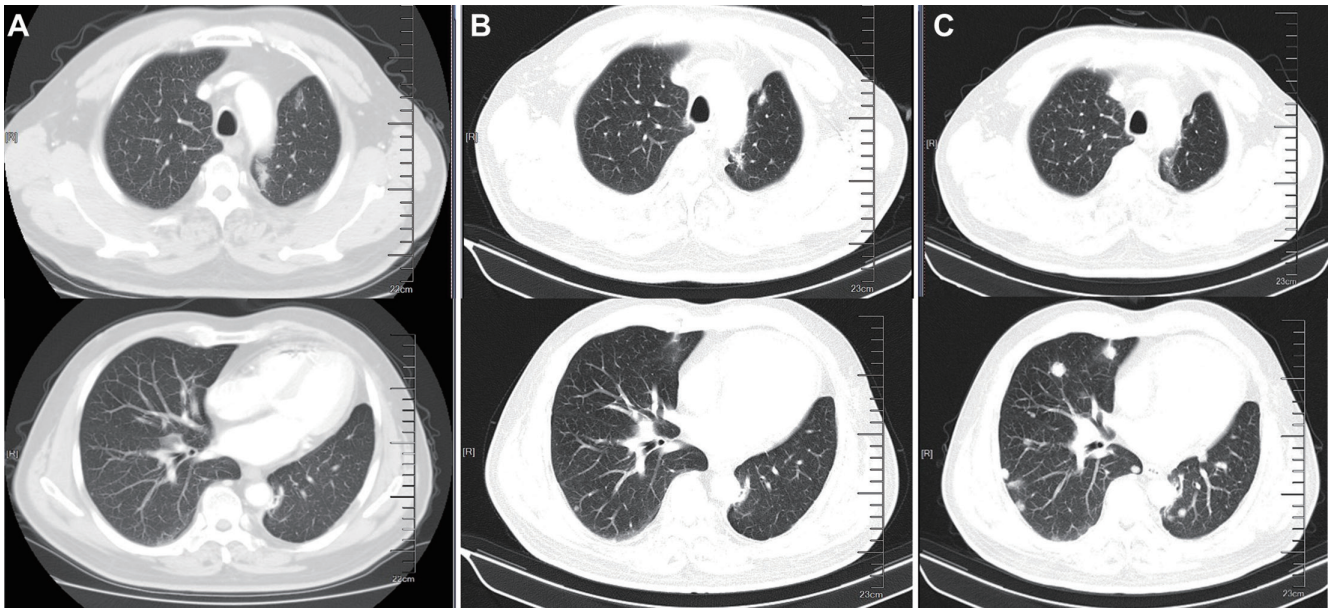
CT scans before and after therapy in a case of *ERCL-RET* fusion. (A) CT scans before Cabozantinib. (B) CT scans after 4 months of treatment with Cabozantinib. (C) CT scans after 10 months of treatment with Cabozantinib. CT, computed tomography.
